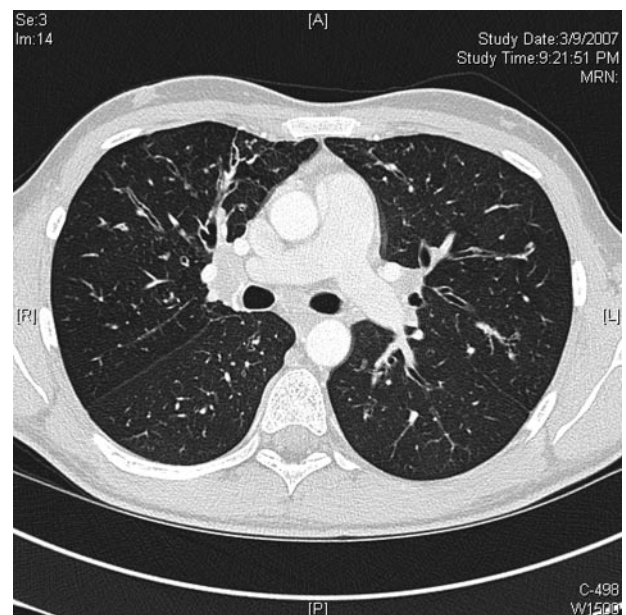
HRCT image from a 25-year-old man with cystic fibrosis and *M abscessus* pulmonary infection. Note that patchy bilateral bronchiectasis and early tree-in-bud infiltrate in the left mid-lung.
